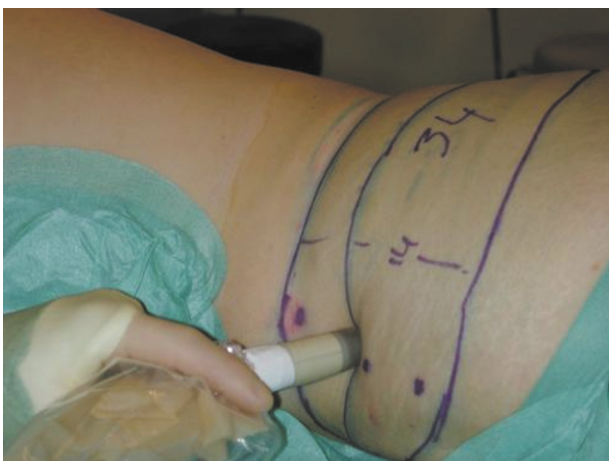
Confirmation of the lumbar artery perforators with a hand-held Doppler.
